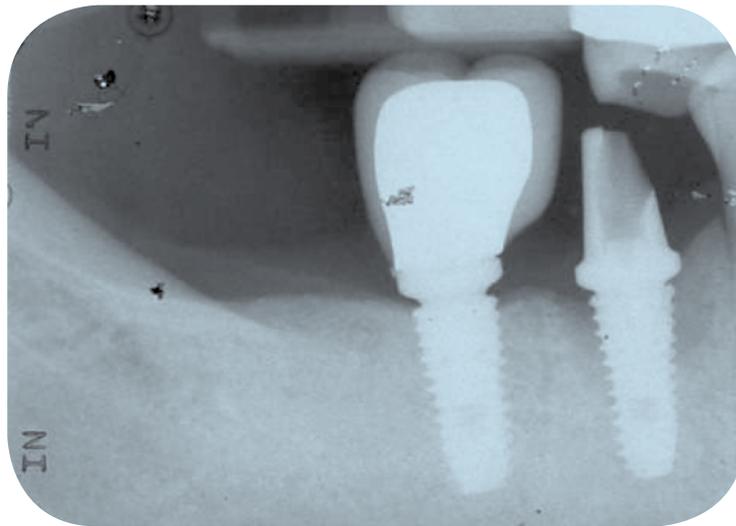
Peri-apical radiograph of implant #45
